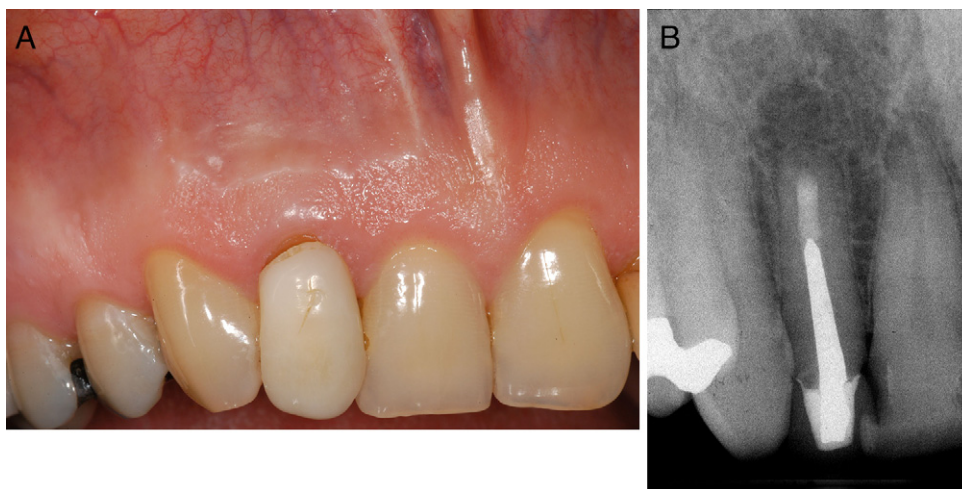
(A) The 1-year clinical picture shows normal and healthy tissues. (B) The radiograph taken 1 year after apical surgery shows the formation of a new periodontal ligament space at the cut root face.
